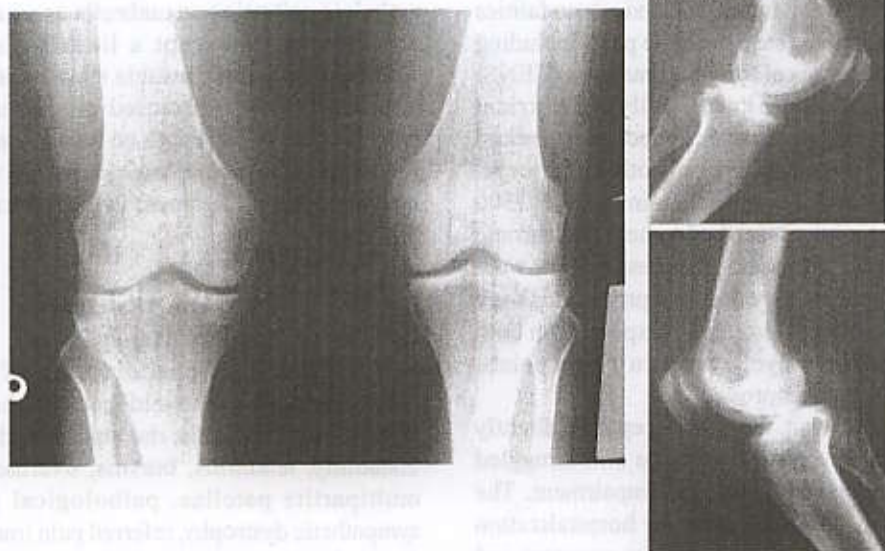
X-ray radiograph of both knees show mild tibial subchondral sclerosis without joint space narrowing or osteolysis.
